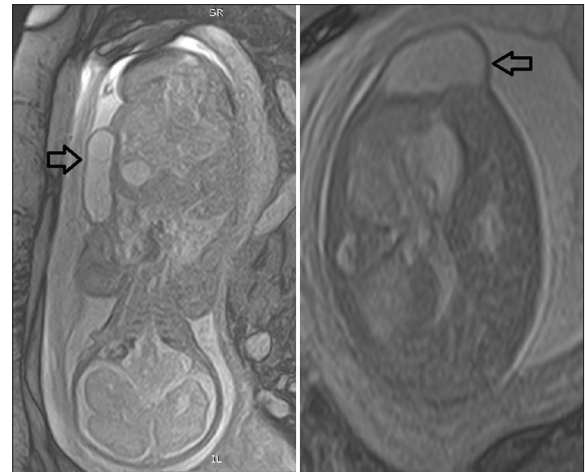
Magnetic resonance imaging at 29 weeks: Coronal and transverse planes of the fetus. The tumefaction is indicated by the arrow
